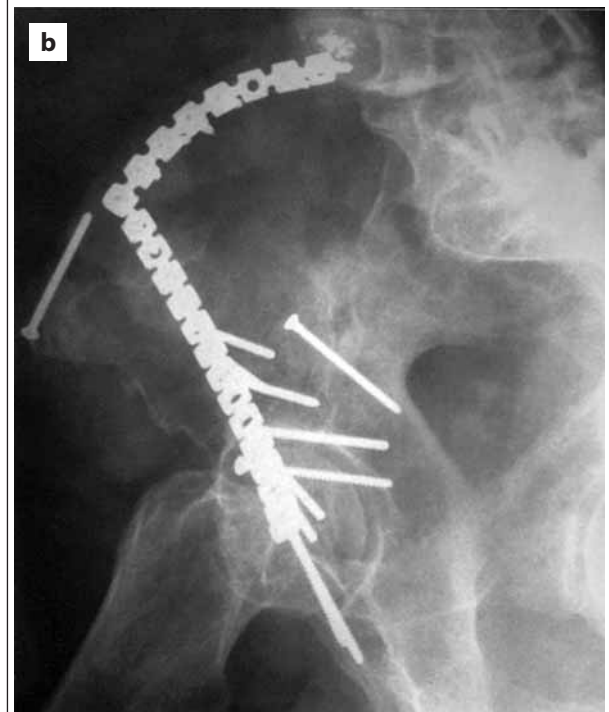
Postoperative X-rays, 12 months after open reduction and internal fixation: a) anteroposterior view; b) oblique iliac view; c) obturator oblique view
